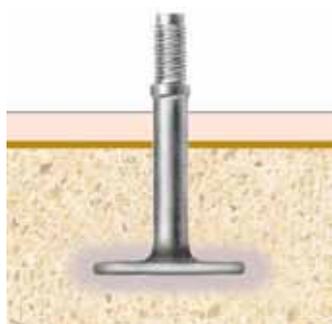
b. A clearly delimited light zone on the radiograph is indicative of an irreversible loosening and detachment of the bone in the interfacial region. In addition, these areas may be superinfected, which additionally stimulates blood circulation. Increased blood circulation as a response to infection is an environmental condition that endangers the presence of bone. Where there is no clinical mobility at all and only a clearly delimited low-density zone is visible radiographically, a pronounced vertical excursive movement of the threaded pin concurrent with sufficient integration of the ring area in the cortical bone may be present at least on one side of the respective jaw.
